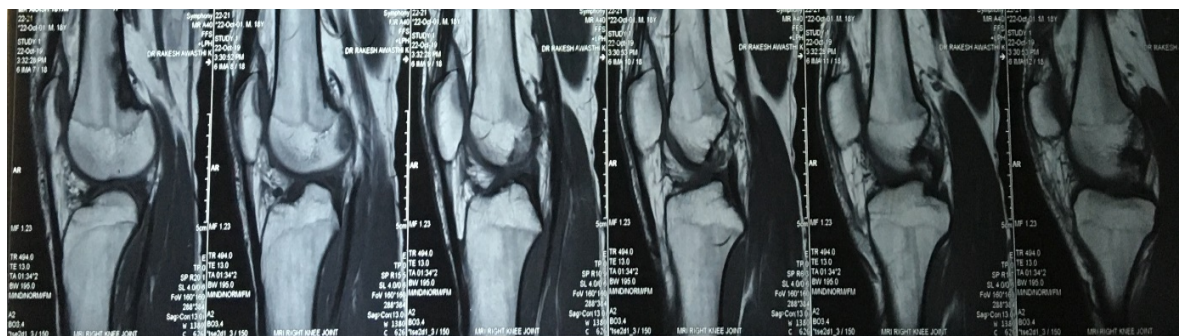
MRI Scan Finding
